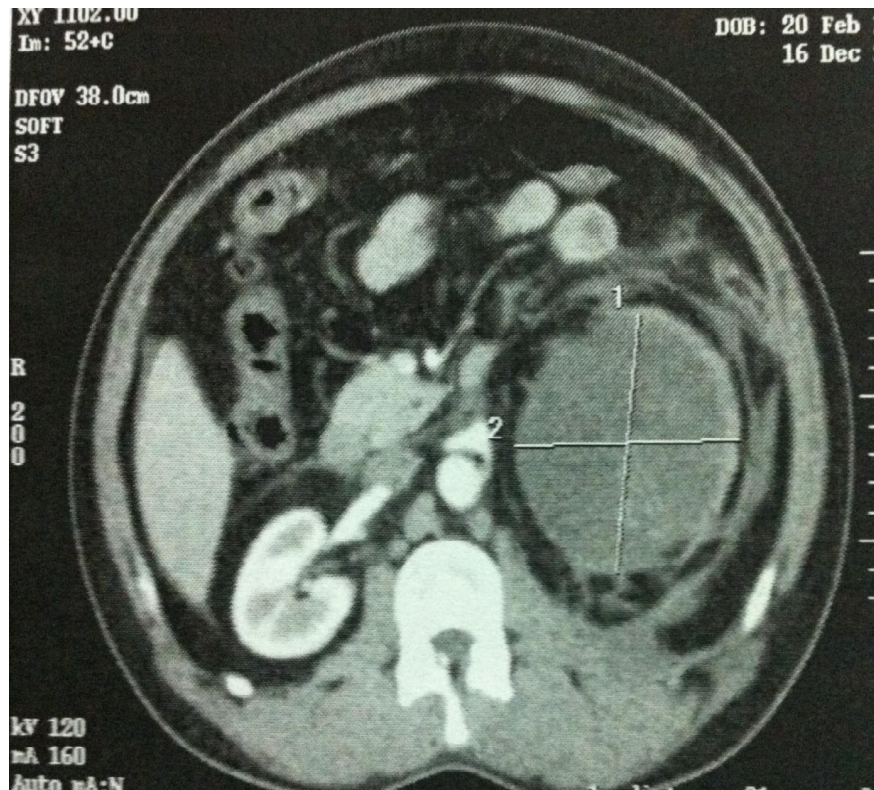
CT scan showing cystic hemorrhagic lesion (type 3 of Bosniak)
